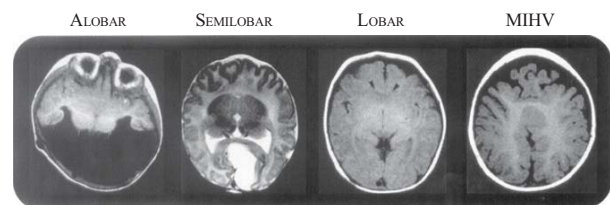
Axial sections through cranial MR images of patients with holoprosencephaly, distinguished by type. MIHV: middle interhemispheric variant. (Adapted from [32] with permission from Elsevier.)
